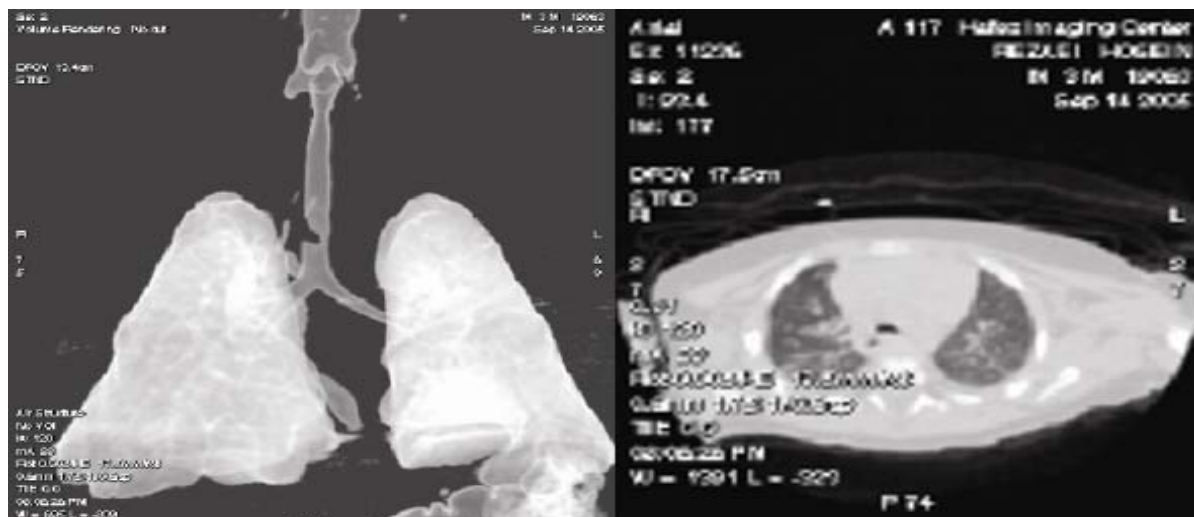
Tracheal bronchus associated with tracheal stenosis and tracheal diverticulum demonstrated by reformatted coronal three-dimensional CT.
